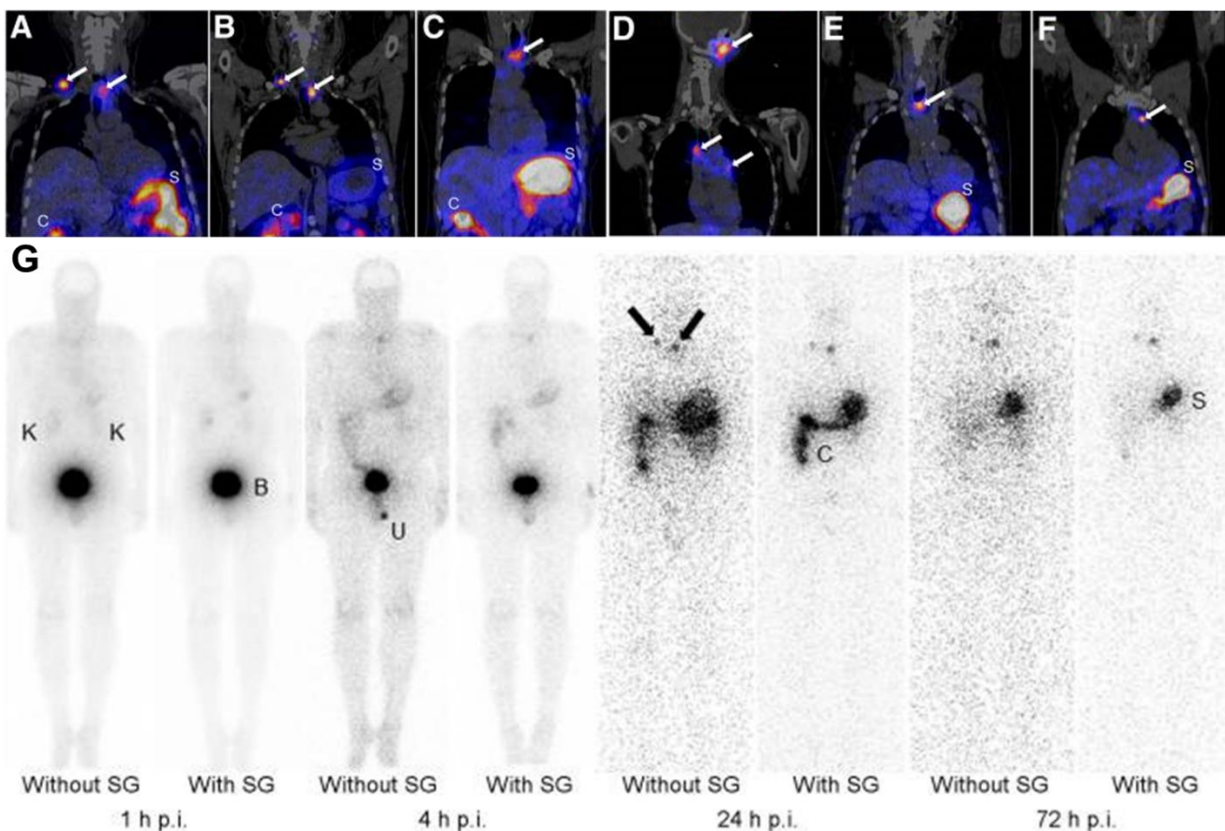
A-F) [^{177}Lu]Lu-DOTA-PP-F11N coronal SPECT/CT scans at 24 h p.i. of 6 different patients G) Exemplary planar scan of one patient injected with either [^{177}Lu]Lu-DOTA-PP-F11N (1 GBq) alone or co-injected with [^{177}Lu]Lu-DOTA-PP-F11N (1 GBq) and succinylated gelatin (SG) at 1 to 72 h p.i. B = urinary bladder; C = colon; K = kidneys; S = stomach; U = urine. Figures have been originally published in JNM and have been combined for this thesis. Copyright © 2020 by SNMMI (161).
